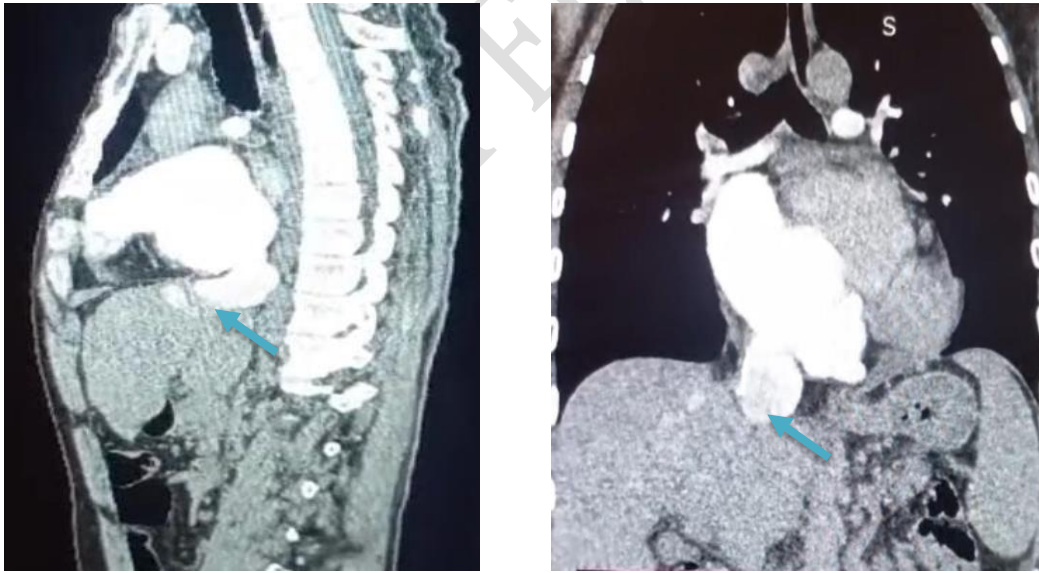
Sagittal and coronal CT images demonstrating dilated IVC stump (➡) receiving hepatic veins.
